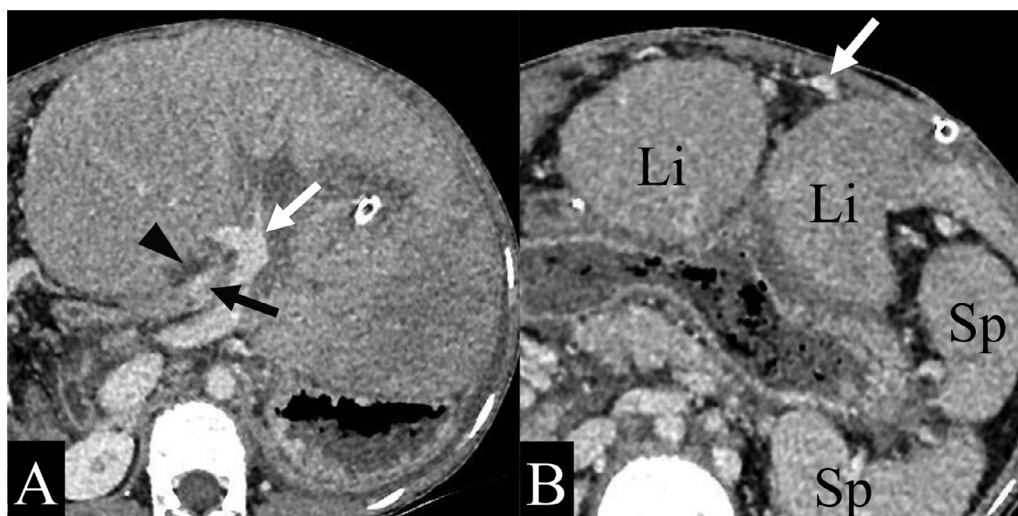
Contrast-enhanced computed tomography (CT) scan of the upper abdomen. (A) CT reveals increased enhancement (black arrow) at the Roux-en-Y (RY) limb (arrowhead) compatible with RY limb varices. The umbilical portion (white arrow) of the left portal vein is also observed. (B) CT taken at 3 cm below (A) reveals an omental vein running directly below the peritoneum. Li, liver; Sp, spleen.
